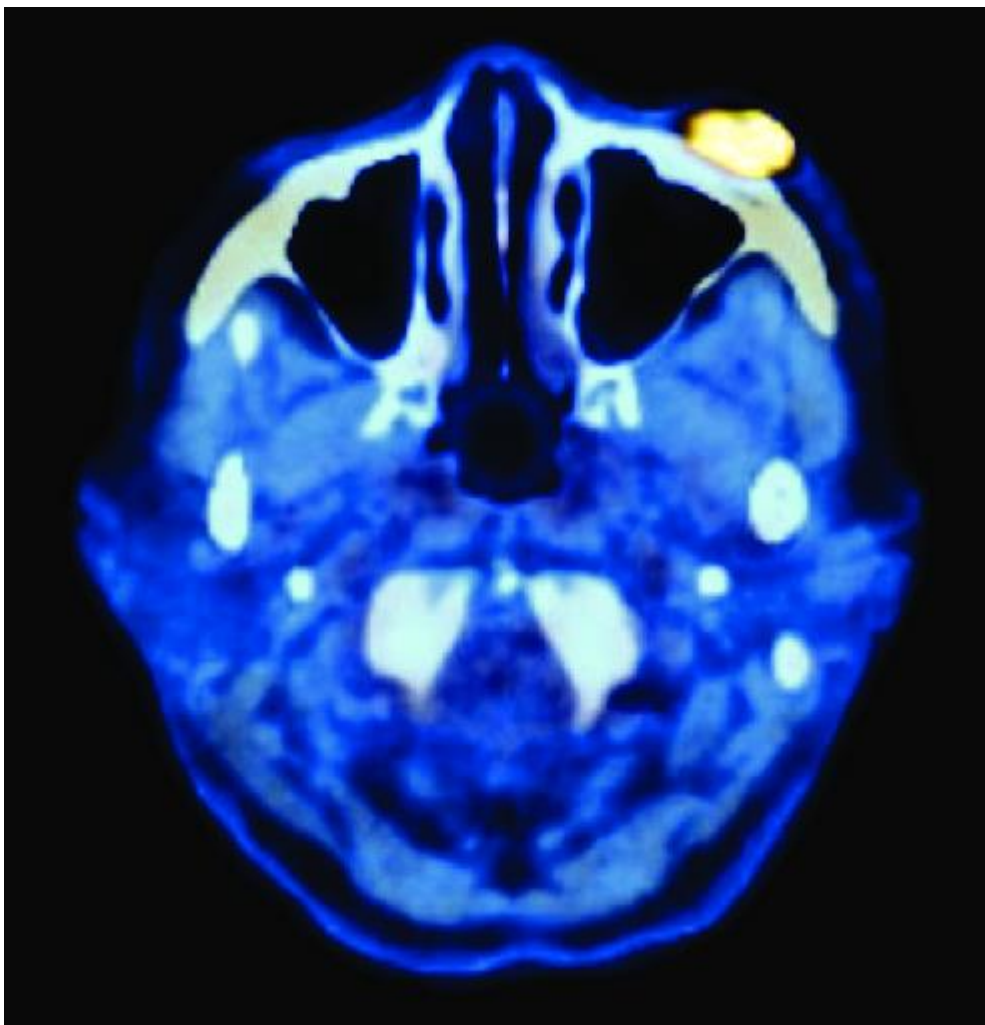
Positron emission tomography-computed tomography showed hypermetabolic lesion on the left cheek area
